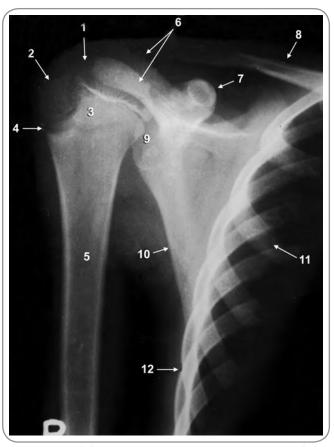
1. Head of humerus. 2. Greater tubercle. 3. Lesser tubercle. 4. Epiphyseal plate of upper end of humerus. 5. Shaft of humerus. 6. Outline of acromion process (partially overlapping the head of humerus). 7 Coracoid process. 8. Clavicle. 9. Glenoid cavity. 10. Lateral border of body of scapula. 11. Medial border of body of scapula. 12. Ribs forming wall of thorax. Radiograph of the region of the shoulder in a child about 10 years old. Ossificaiton of the upper end of the humerus is not complete. The centes for the head, the greater tubercle and the lesser tubercle are seen separately. The epiphyseal plate separating the upper end from the diaphysis is clearly seen. The shadow of the scapula is overlapped (in its medial part) by the thoracic cage (made up of r bs). The med al margin of the scapula can be made out (as the ribs appear lighter where they overlap the scapula). The acromion, the coracoid process and the clavicle can be distinguished. The tip of the coracoid process is seen as a circular area as it is viewed head on
